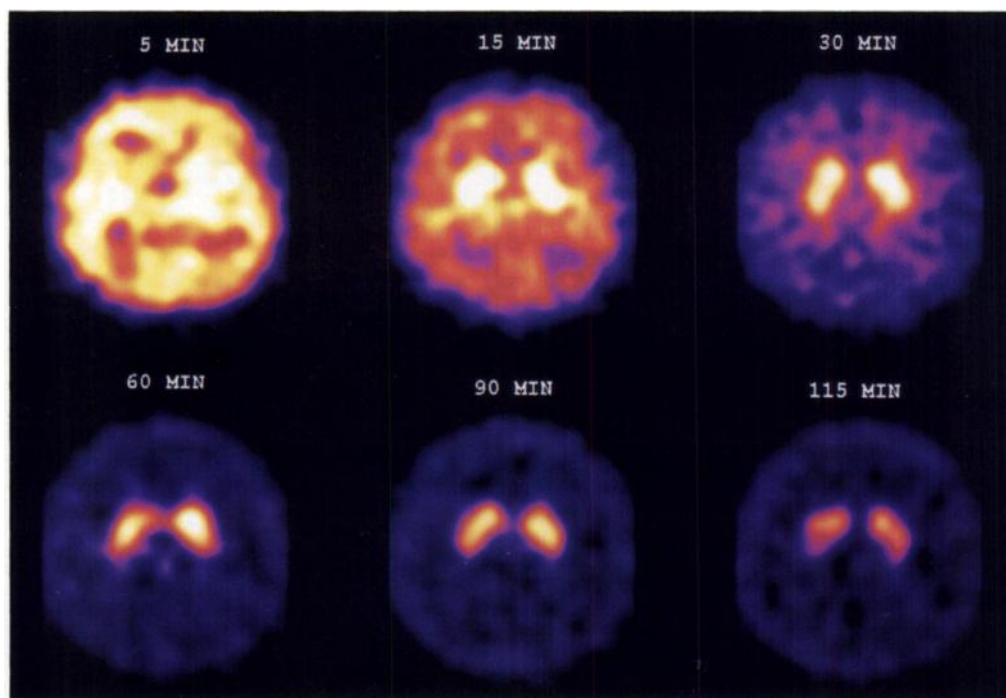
Activity distribution of ^{123}I -IPT after injection of 6.96 mCi (257.52 MBq) into a 49-yr-old female, normal control. Acquisitions were obtained for 5 min each with a triple-headed SPECT camera over 2 hr and reoriented so that the AC-PC line corresponded to the transaxial axis of the data set. Left BG-to-OCC ratios were 2.72, 4.15, 5.23 and 5.43 at 30, 60, 90 and 115 min, respectively. Right BG-to-OCC ratios were 2.54, 3.76, 5.11 and 5.16 at 30, 60, 90 and 115 min, respectively.
